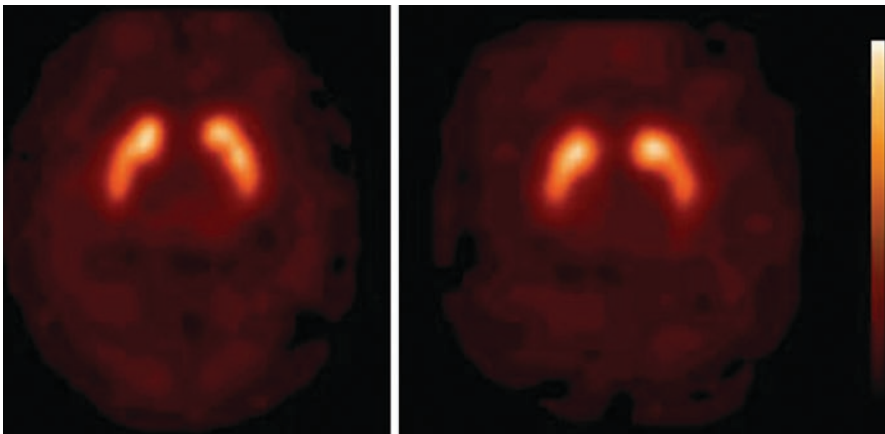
[¹²³I]FP-CIT SPECT scan obtained (3 h after injection) in a 21-year-old healthy female control (*left side*) and in a 78-year-old healthy female control (*right side*). Striatal binding of [¹²³I]FP-CIT is symmetrical and clearly visible in both the caudate nucleus and putamen, in the young as well as the aged healthy control
